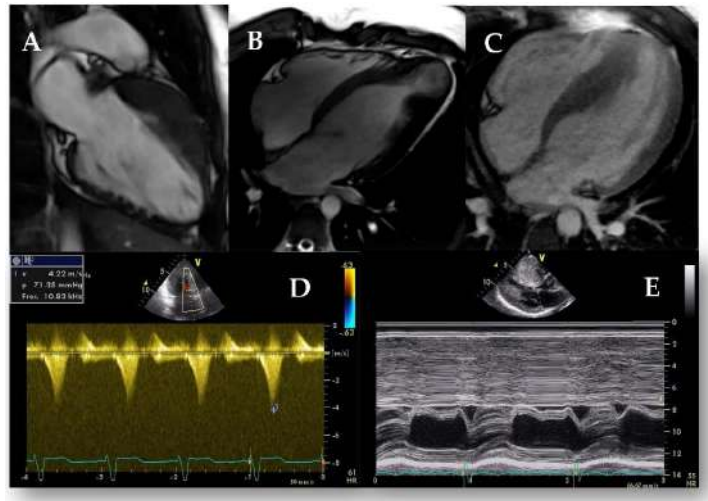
Ancillary signs in HCM. (A) Myocardial crypts in the inferior wall. (B) Apical aneurysm in a patient with apical HCM. (C) Apical insertion of the papillary muscles in a patient with septal HCM. (D) Outflow tract obstruction measured on Doppler CW, note the dagger-shaped curve. (E) SAM evidenced on M-mode: see the movement of the anterior mitral leaflet towards the septum in systole.
